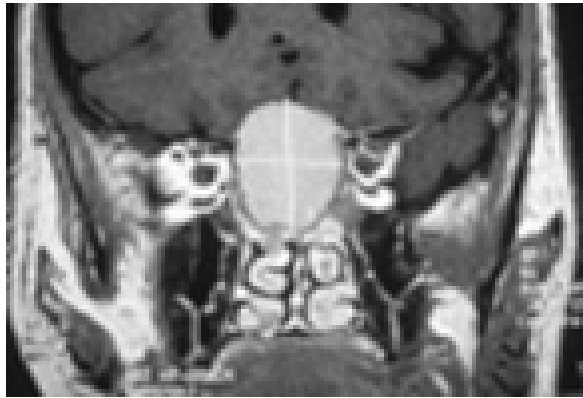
Coronal MRI brain- showing pituitary tumour
